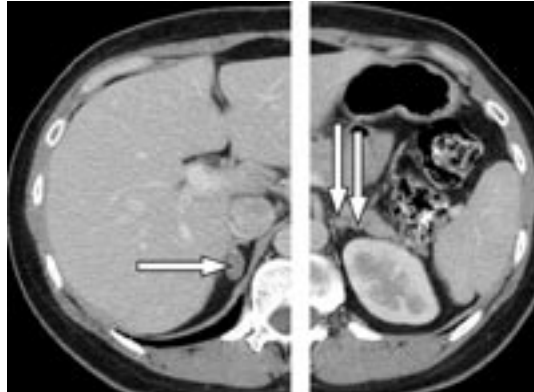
Adrenal computed tomographic scan of a 37-year-old woman with poorly controlled hypertension despite taking 3 antihypertensive drugs. The scan shows an 18-mm right adrenal nodule (arrow, left panel) and 2 left adrenal nodules of 7 mm and 4 mm (arrows, right panel). Adrenal venous sampling lateralized the aldosterone secretion to the right adrenal gland. A cortical adenoma (20 mm × 17 mm × 12 mm) was found at laparoscopic right adrenalectomy. The patient's postoperative plasma aldosterone concentration was low, and her blood pressure was normal without the aid of antihypertensive medications at 18 months after surgery.
